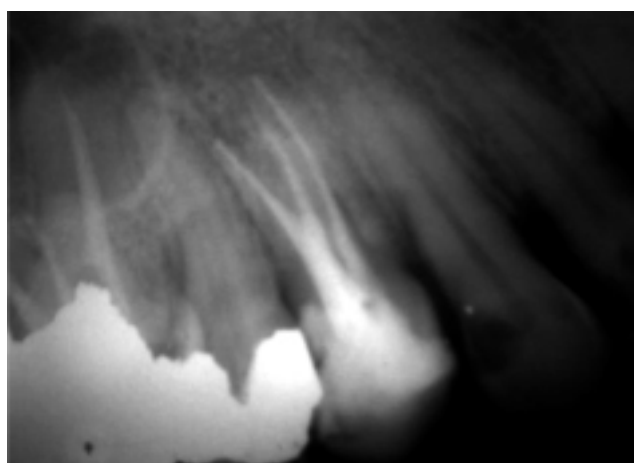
Radiograph after retreatment of three canals.
